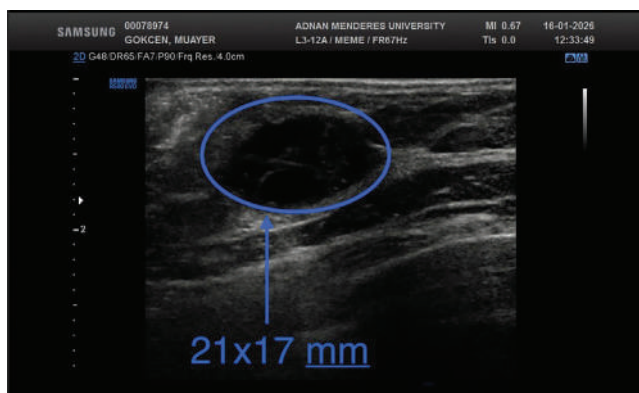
Ultrasonography (USG). Preoperative USG image of the lesion.
